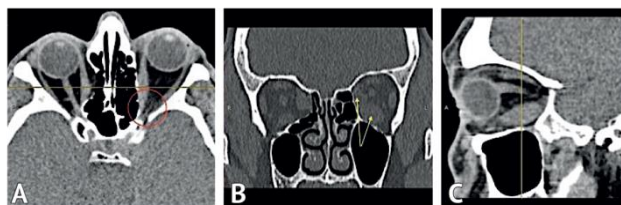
Preoperative CT images of patient M. A — axial projection; B — front view; C — sagittal projection; the yellow arrows indicate the enlarged oculomotor muscles of the left orbit, the red circle indicates the area of compression of the optic nerve in the apex of the left orbit
